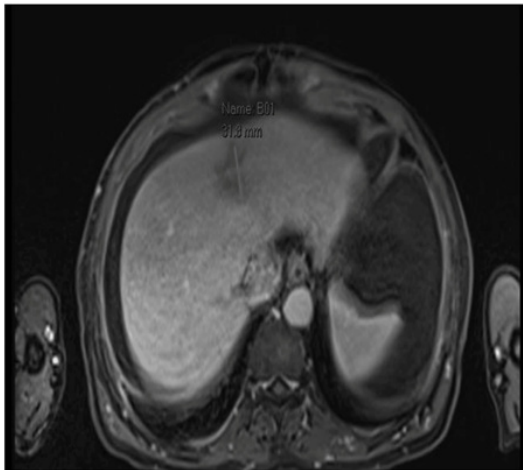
MRI Liver showing a 31.8 mm ill-defined area (labelled B01) of low intensity bordering segment 4A and 2 of the left lobe of the liver, best demonstrated on the portal venous phase series.
